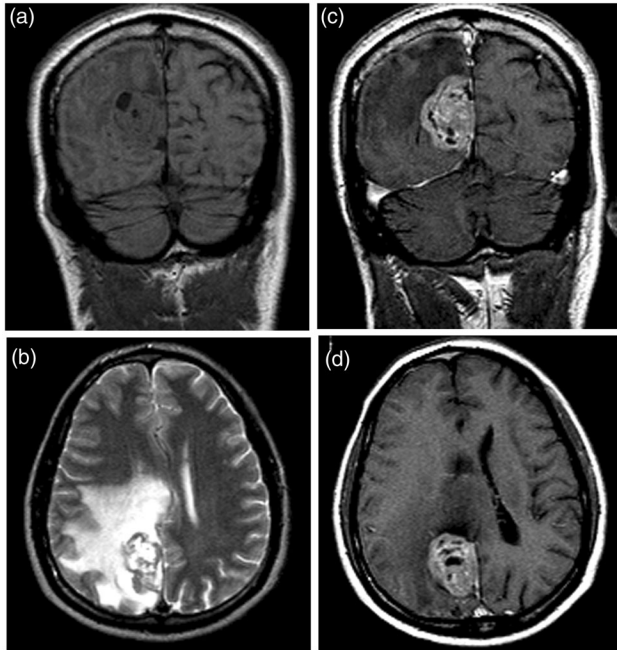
Preoperative MRI brain: (a) T1w coronal image showing the tumour isointense with brain (b) T2w axial image showing white matter edema in the adjacent brain (c,d) post-contrast coronal and axial images showing a 5 × 4 × 5 cm well-defined enhancing mass with a broad surface abutting the falx in its middle third.
